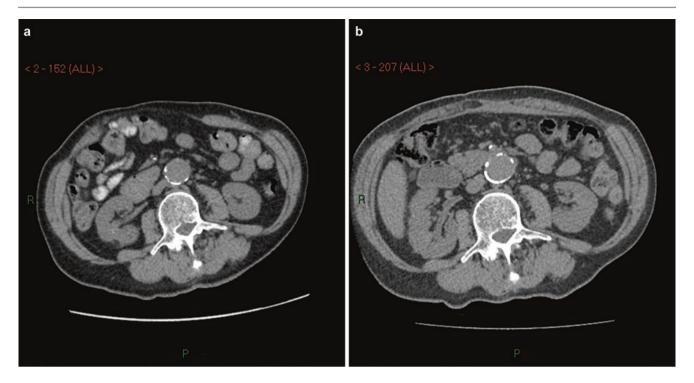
(a) CT scan prior to a peritoneal flap hernioplasty repair showing wide separation of the rectus muscles. (b) Postoperative CT scan of the same patient showing the extent to which the rectus muscles have been drawn back towards the midline
